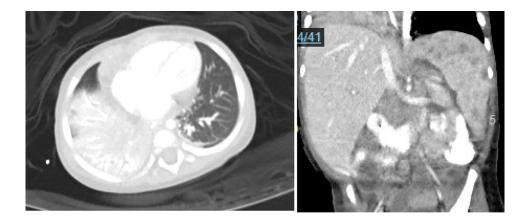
Imaging from day 16 of illness shows consolidation in the right middle and lower lobes. Computed tomography (CT) angiography of the chest (left) and hypodense splenic lesions and porta hepatic and portacaval adenopathy. CT of the abdomen (right).
